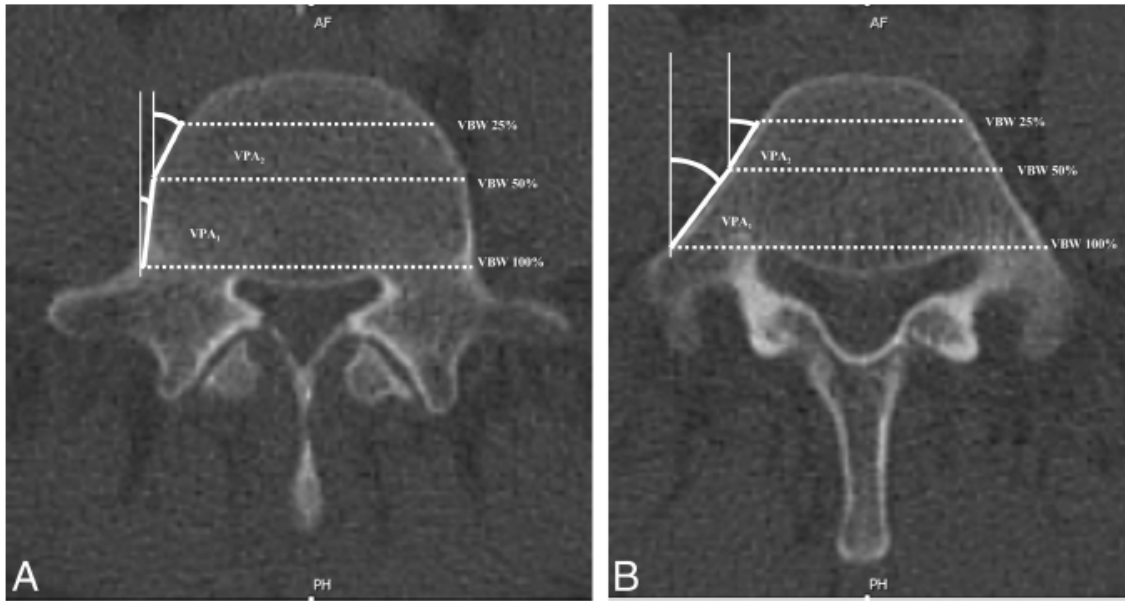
A, Vertebral body width in the posterior part of vertebral body ($VBW_{100\%}$), in the middle of the vertebral body ($VBW_{50\%}$), and over the line that passes at 25% of the vertebral body length ($VBW_{25\%}$), the vertebral perimetral angle proximal (VPA_1), and distal (VPA_2) in a CT slice in the upper part of the pedicle. B, Vertebral body width in the posterior part of vertebral body ($VBW_{100\%}$), in the middle of the vertebral body ($VBW_{50\%}$), and over the line that passes at 25% of the vertebral body length ($VBW_{25\%}$), the vertebral perimetral angle proximal (VPA_1), and distal (VPA_2) in a CT slice in the lower part of the pedicle.
